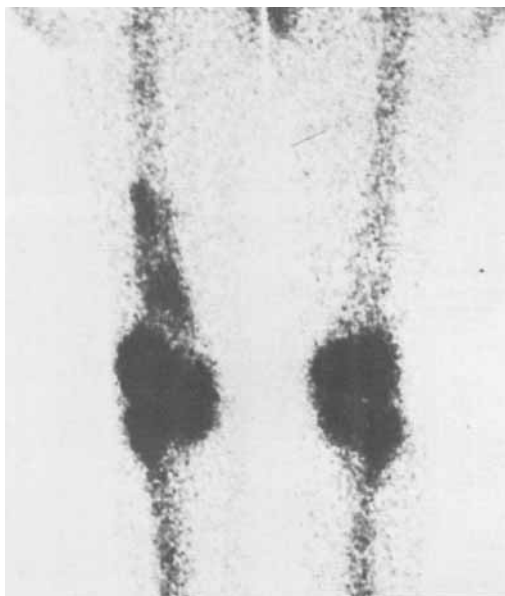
^{99m}Tc diphosphonate scintigraphy of the transplant shows increased activity 5 months post-operatively as a sign of early creeping substitution in the right distal femur (Case 9).
